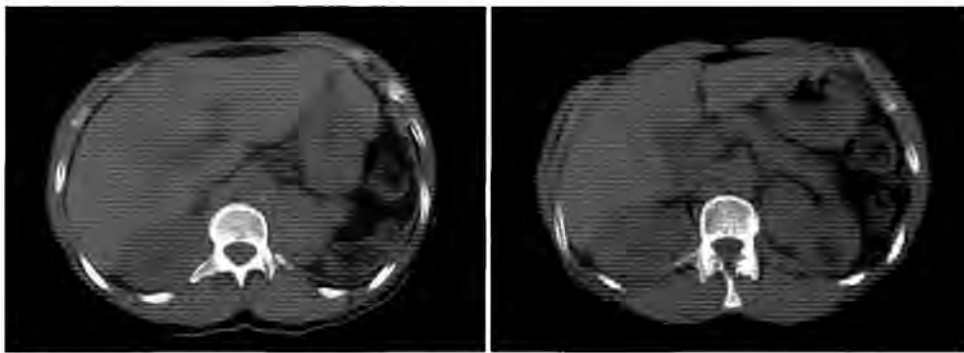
Noncontrast CT demonstrates a homogenous left adrenal gland mass.
